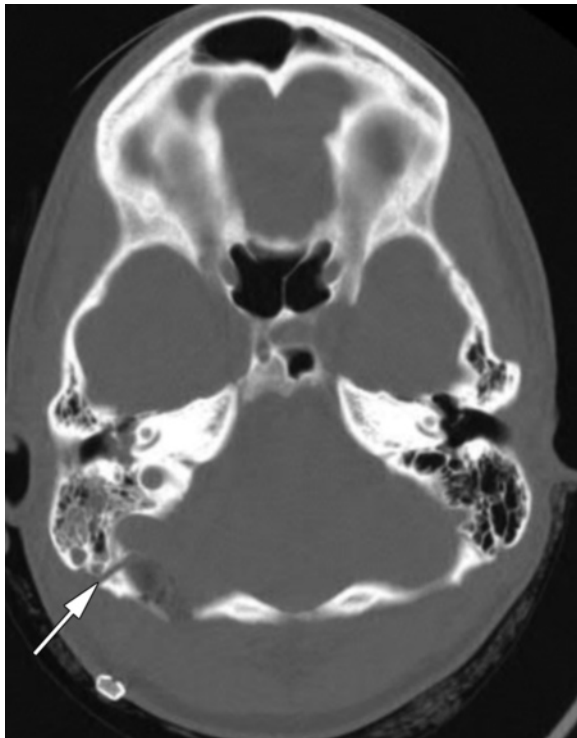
CSF leak. Axial nonenhanced CT scan (bone algorithm) obtained following suboccipital resection of a vestibular schwannoma shows a postoperative CSF leak. A craniotomy defect is seen traversing mastoid air cells (arrow), allowing an egress of CSF into the middle ear cavity.
